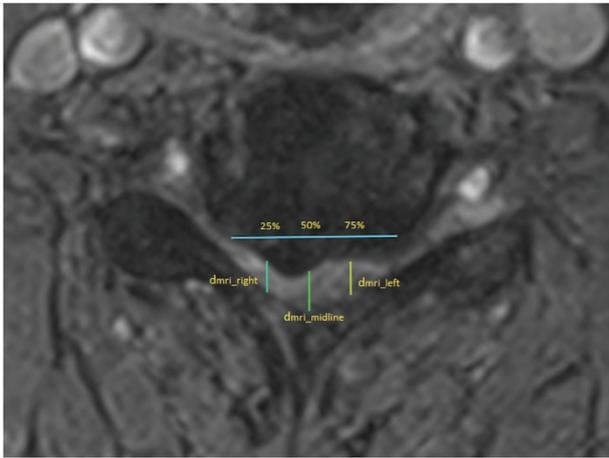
An axial T₂ MRI section of UL_{aboriginal} patient #4 at the C₅₋₆ level and the related spinal canal dimensions.
